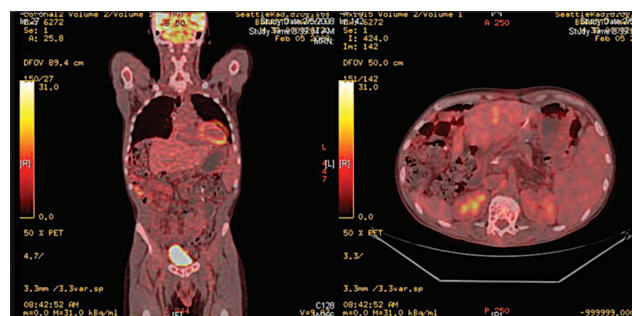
February 2008 PET/CT scan showed a small lesion in the pancreas and a 1.8-cm lesion in the central part of the liver, but no evidence of hypermetabolic activity.
